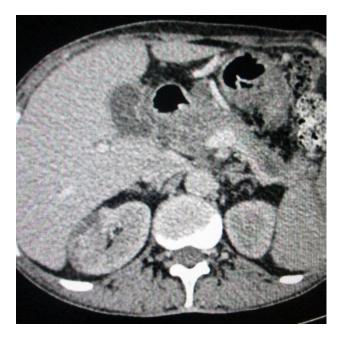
Contrast enhanced CT scan of the abdomen showing multiple hypodense areas within the head of the pancreas and tail with bulky appearance of head and peripancreatic fat stranding suggestive of acute pancreatitis.
